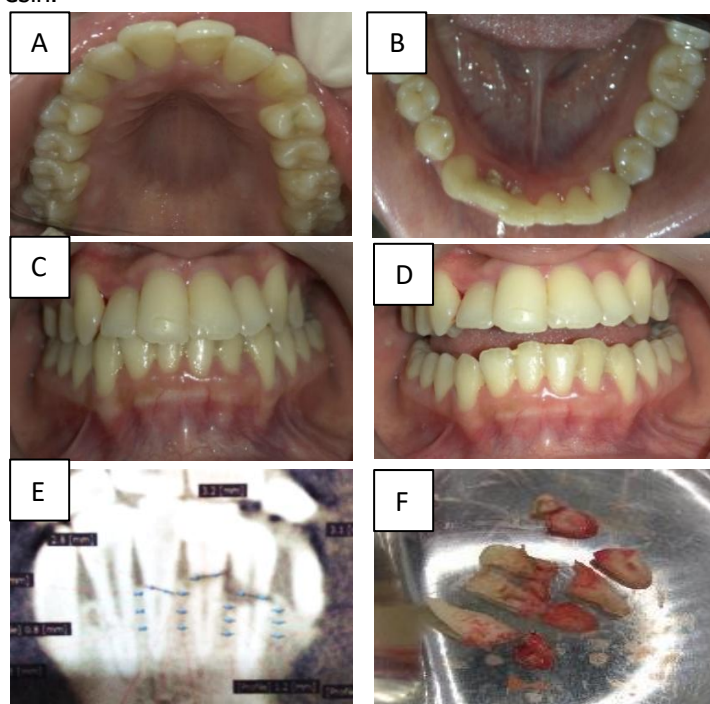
Preliminary oral condition; A. maxillary occlusal; B. mandibular occlusal; C. maxilla and mandibular teeth occlusion; D. open occlusion; E. CBCT showed the fracture location; F. tooth fracture fragments.
